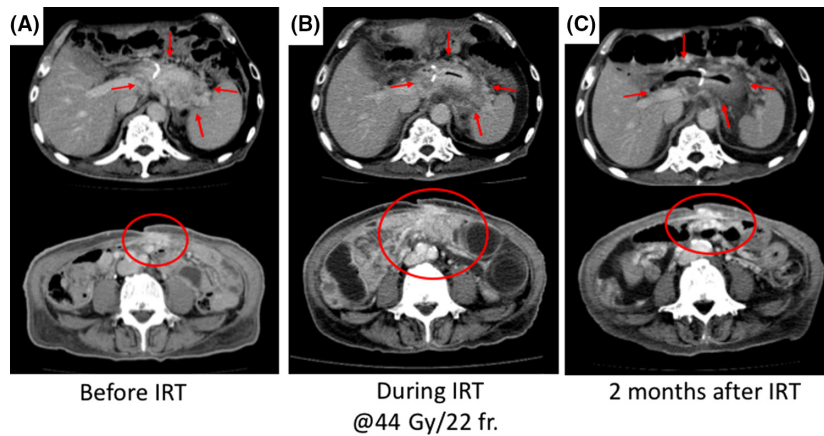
CT images of local recurrence and peritoneal dissemination before, during, and after immunoradiotherapy. (A) CT images before immunoradiotherapy: 2 months after the first paclitaxel treatment followed by immunotherapy. Progression of the local recurrence lesion and peritoneal dissemination was confirmed. (B) CT image was acquired during immunoradiotherapy at 44 Gy in 22 fractions point. Shrinkage of the locally reoccurred tumor (red arrow) and progression in peritoneal dissemination (red circle) were observed. (C) CT image was taken 2 months after the start of the therapy. A complete remission of the locally recurrent tumor and an abscopal effect were observed. IRT, immunoradiotherapy.
